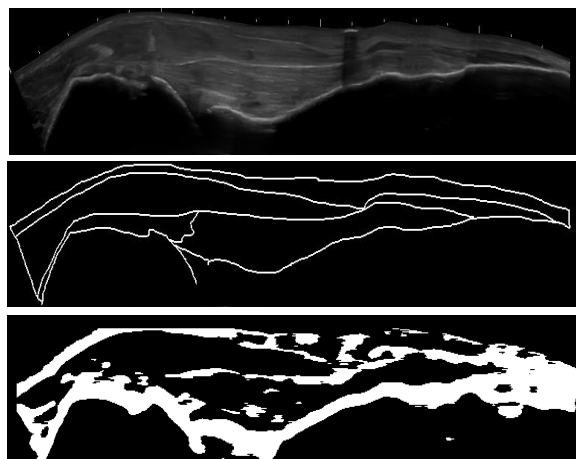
from top to bottom, input ultrasound image (sample4), EGT and output ultrasound image.
